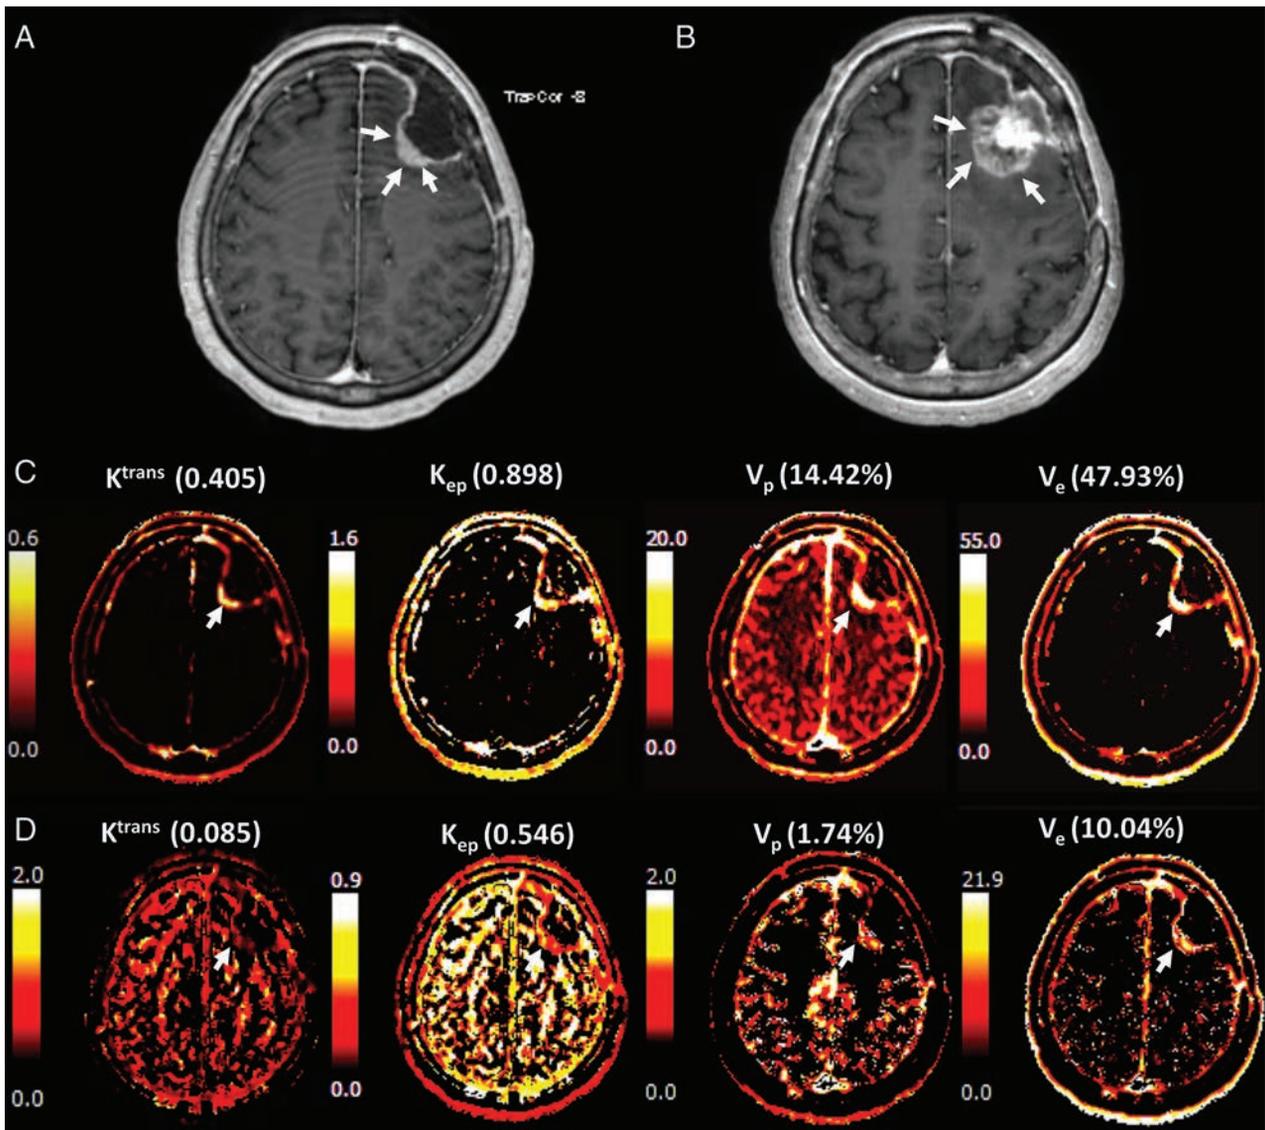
A 68-year-old female patient with surgically proved glioblastoma presented *A*, a newly appeared enhancing nodule on DCE-MR imaging taken 1 month after temozolomide chemoradiation. The lesion was not identified on the postoperative MR imaging. *B*, The lesion was markedly increased after 6 cycles of temozolomide chemotherapy, implying that the lesion was true progression according to the Response Assessment in Neuro-Oncology criteria. The pharmacokinetic DCE maps, especially those for K^{trans} and K_{ep} , showed a bright signal from both the *C*, fixed T1 and *D*, measured T1 methods.
